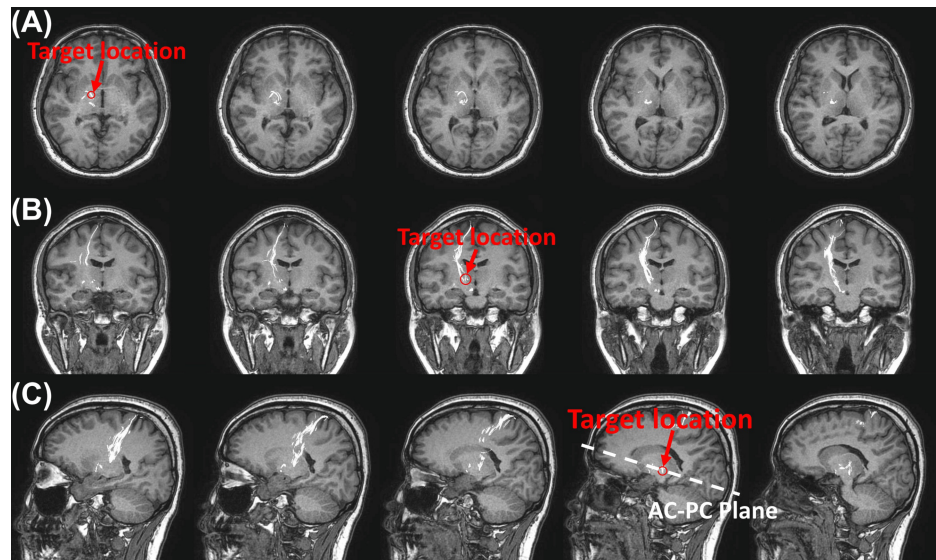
Two-dimensional projection of tractography onto three-dimensional T1-weighted MRI for target measurement (right PTT).
